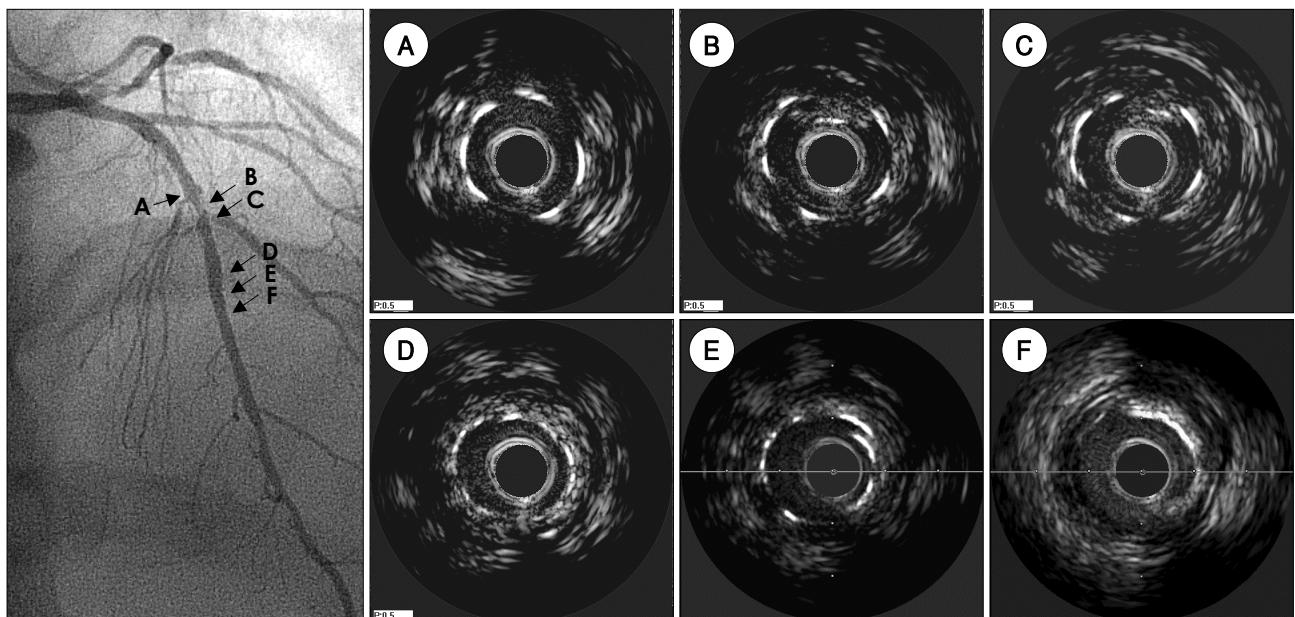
Intravascular ultrasound image of the left anterior descending coronary artery at 6-months follow-up. In A and D, good stent struts apposition to the vessel wall without neointimal hyperplasia in the proximal and distal from the stenosis, respectively. B & C: at the restenotic site, there are significant neointimal hyperplasia in the 12 O'clock, where the fractured stent strut is visible at this cross-section indicating the stent fracture. E & F: kinked and collapsed stent strut (E) due to the distal calcified lesion (F).
